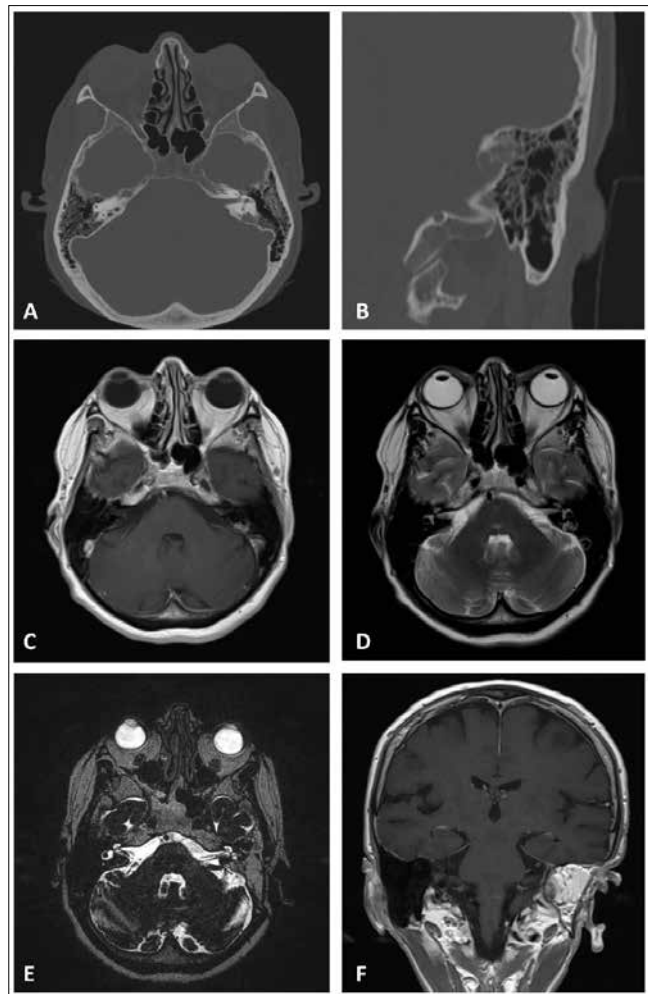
Small left endolymphatic tumour. A: axial bone CT scan with erosion in posterior ridge of petrous bone. B: bone erosion and tumour seen in retrolabyrinthine area in a coronal plane. C: axial contrast-enhanced T1 MRI showing tumour in petrous bone, in the prestigmoid-extradural area. D: axial T2 MRI showing hyperintense signal in tumour foci. E, F: no residual disease evident on T2 high-resolution and contrast-enhanced T1 MRI.
